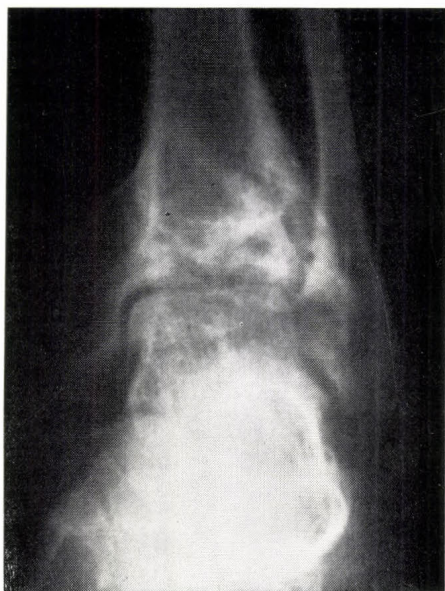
Roentgenogram of the talocrural joint one year following the accident
